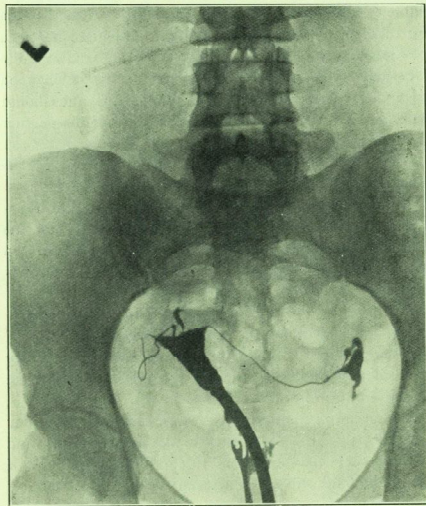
X-RAY PHOTOGRAPH OF UTERUS AND FALLOPIAN TUBES AFTER INJECTION OF LIPIODOL. BOTH FALLOPIAN TUBES HAVE FILLED NORMALLY.
